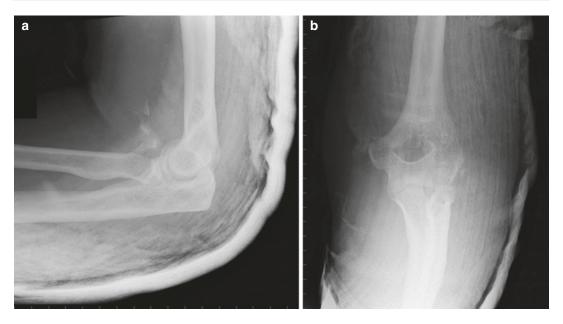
Left elbow dislocation with comminuted radial head fracture in a 43-year-old man. Preoperative X-rays, (a) lateral view and (b) anteroposterior view, obtained after dislocation reduction and cast immobilization
